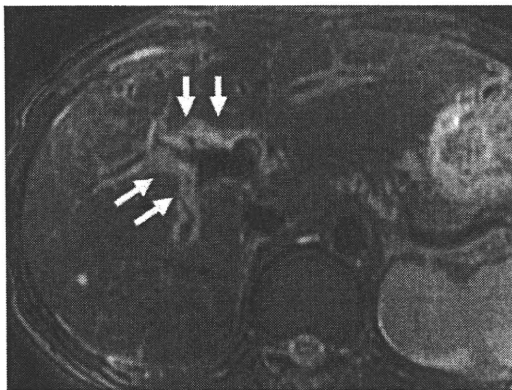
T2-weighted fat-saturated turbo spin-echo (TSE) image (repetition time/echo time [TR/TE] = 4600/99 ms) in a patient with chronic hepatitis due to autoimmune hepatitis shows regions of high signal intensity bands paralleling the portal vessels (arrow).
